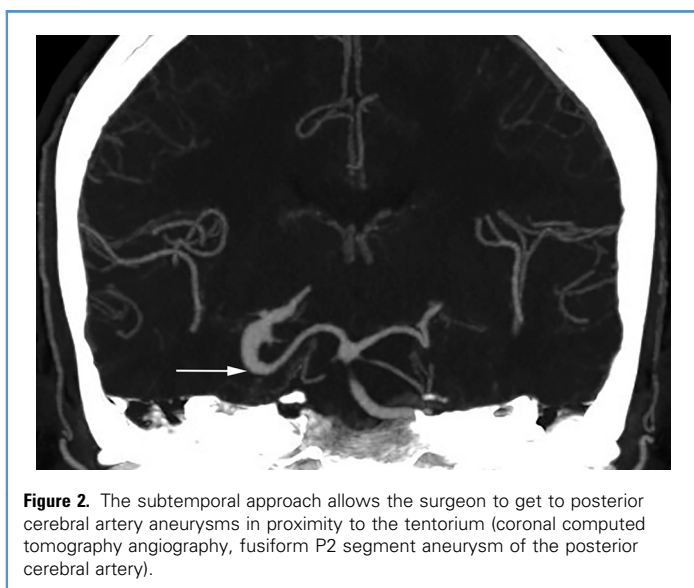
The subtemporal approach allows the surgeon to get to posterior cerebral artery aneurysms in proximity to the tentorium (coronal computed tomography angiography, fusiform P2 segment aneurysm of the posterior cerebral artery).
